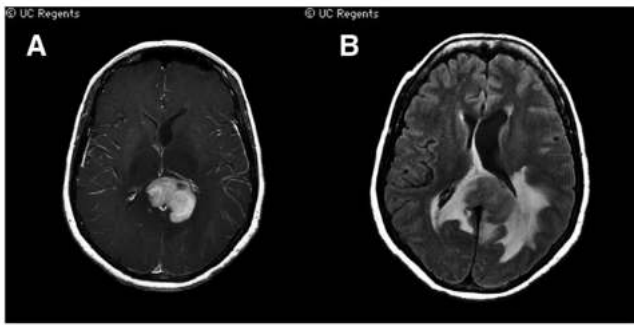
Characteristic radiographic features of PCNSL on magnetic resonance imaging. (A) A T1 axial, postgadolinium image depicts a periventricular contrast-enhancing lesion with near-uniform contrast enhancement, vasogenic edema and mass effect, in displacement of the lateral ventricles. Lesional contrast enhancement using MRI is used for response assessment. (B) A flair signal abnormality demonstrates the extent of vasogenic edema. (Courtesy Soonmee Cha, MD, University of California–San Francisco).
